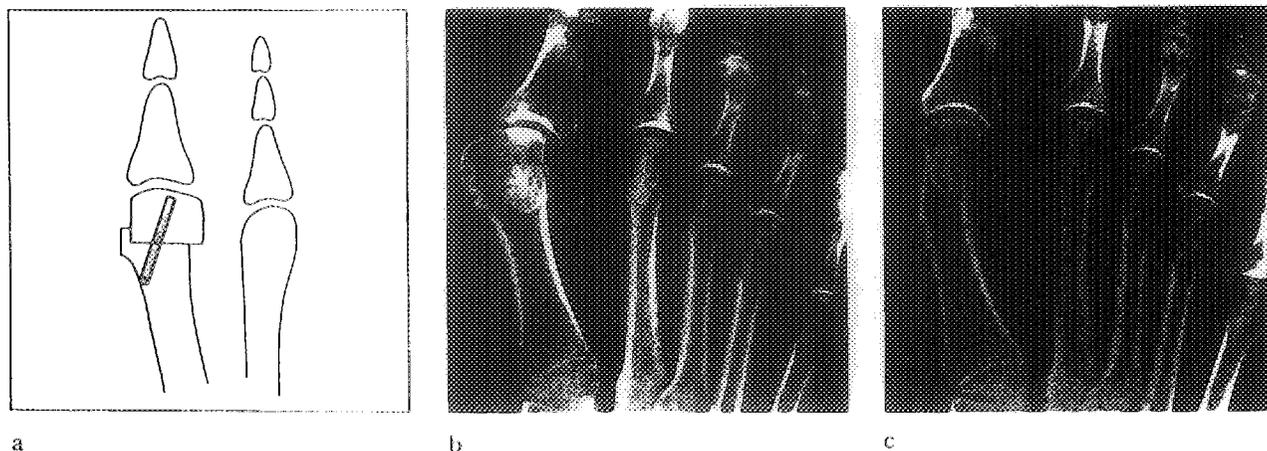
Chevron osteotomy. Fixation of the metatarsal head (a). Radiograph with full weight bearing of a foot with moderate hallux valgus seen preoperatively (b) and one year after Chevron osteotomy and fixation with one 2 by 25 mm BIOFIX®-rod (c). The intermetatarsal angle has been corrected from 17 to 9 and the metatarsophalangeal angle from 40 to 18 degrees.
